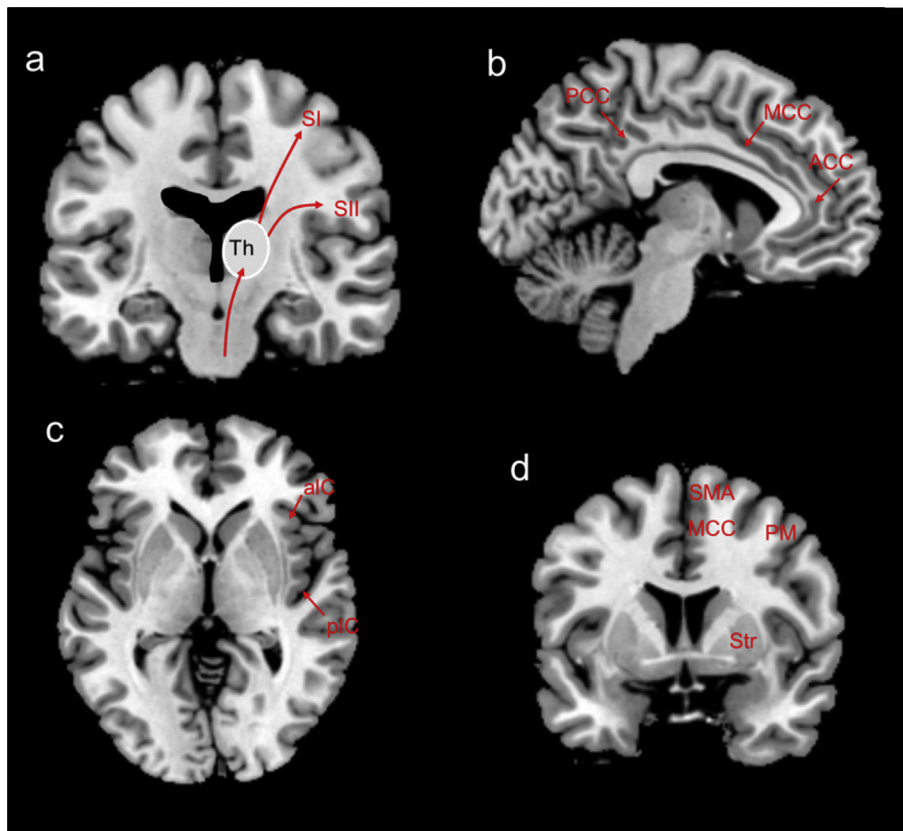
Brain regions associated with itch. SI, primary somatosensory cortex; SII, secondary somatosensory cortex; Th, thalamus; ACC, anterior cingulate cortex; PCC, posterior cingulate cortex; aIC, anterior part of the insular cortex; pIC, posterior part of the insular cortex; SMA, supplementary motor area; PM, premotor cortex; MCC, midcingulate cortex; Str, striatum. MRI images: 2D images of the brain template implemented in the MRICron software (<http://www.mccauslandcenter.sc.edu/mricron/>).
